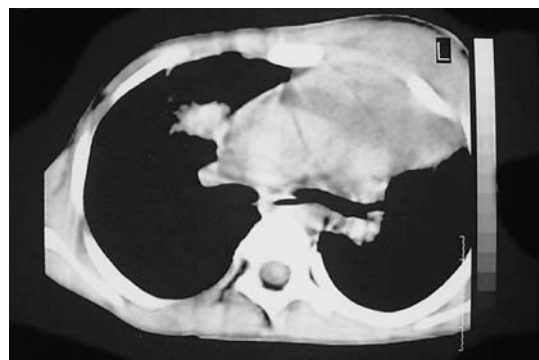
Contrast-enhanced CT scan of the thorax obtained at the level of the left hilus and pulmonary truncus shows a soft tissue mass at the left anterior mediastinal region, left upper and middle zones, left anterior thorax wall, and a 2-cm nodular opacity at the right perihilar anterior localization.
